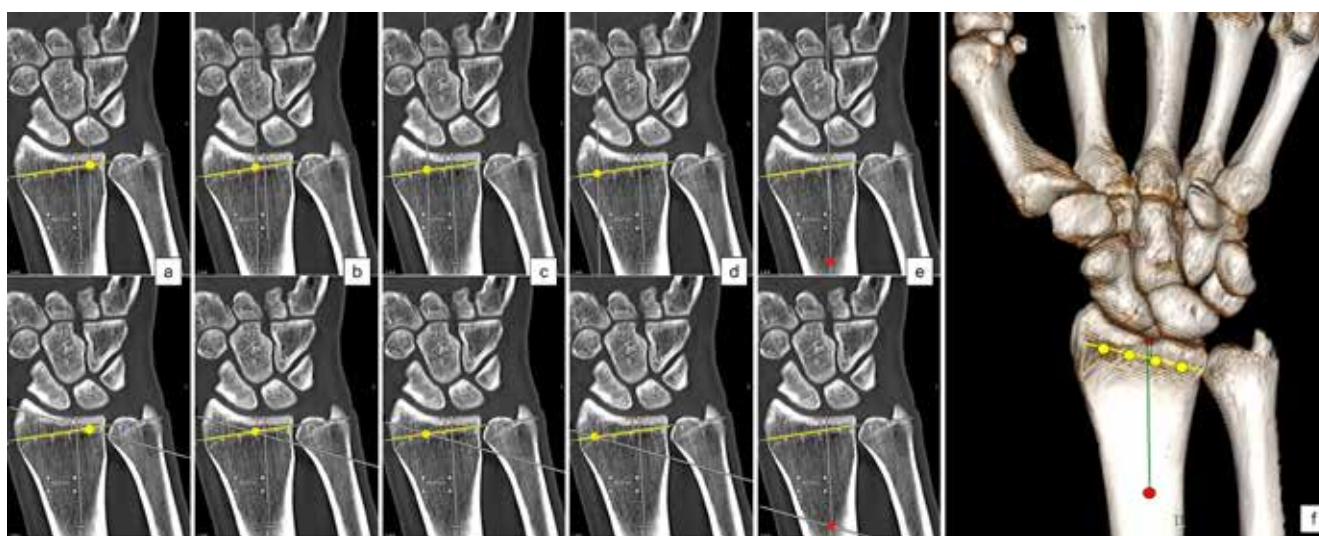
Determination of watershed line, epiphyseal and diaphyseal screw holes in coronal (a-e) and 3-D (f) CT images.
